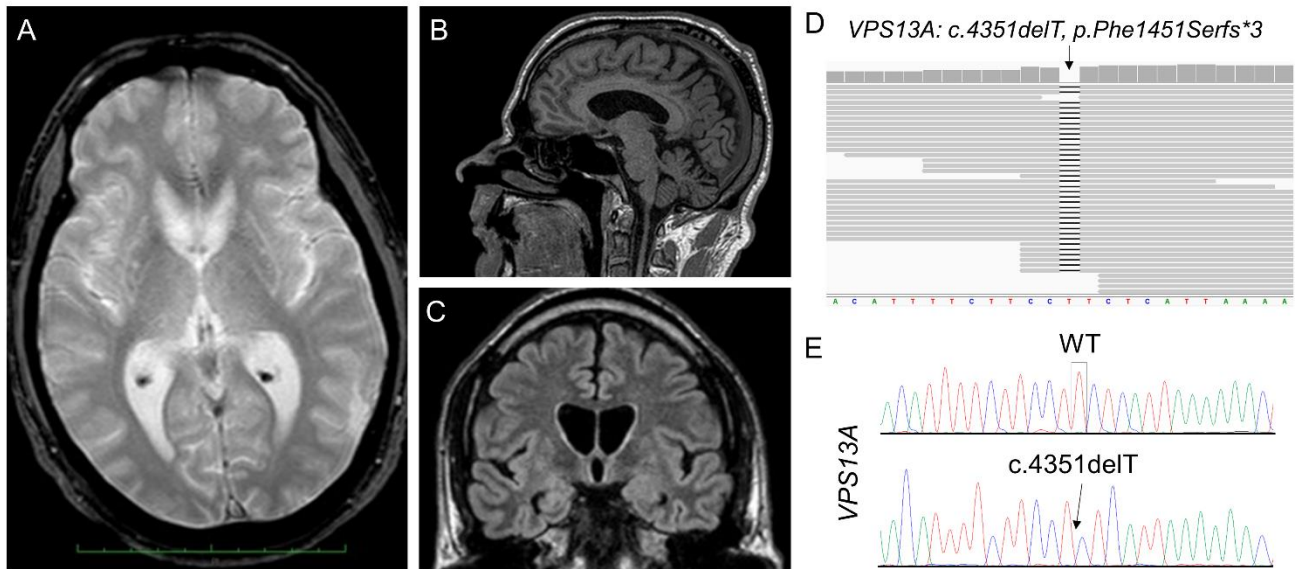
A-C) Brain MRI of the patient: axial T2-weighted sequence showing symmetrical hyperintensity of the putamen (A), sagittal T1-weighted sequence showing moderate atrophy of the cerebellar vermis (B), coronal T1-weighted sequence revealing symmetrical atrophy of the caudate nucleus (C); D) IGV viewer snapshot of genomic .bam file demonstrating the homozygous deletion of a single thymidine (T) in position c.4351 of the *VPS13A* gene; E) Sanger validation of the identified homozygous *VPS13A* single base deletion: wild-type (WT) in the upper panel and mutated in the lower panel.
